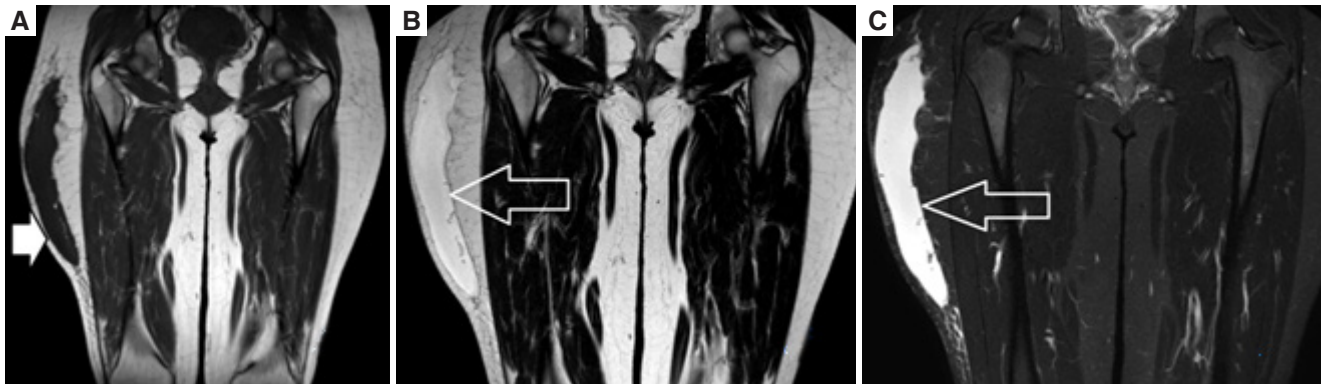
Magnetic resonance images. (A) T1W image shows hypointense collection under the skin but overlying the fascia (white arrow); (B) T2W image shows the collection as hyperintense with well defined margins (hollow white arrow); (C) STIR images reveal the collection as hyperintense with suppression of surrounding fat (hollow white arrow)
